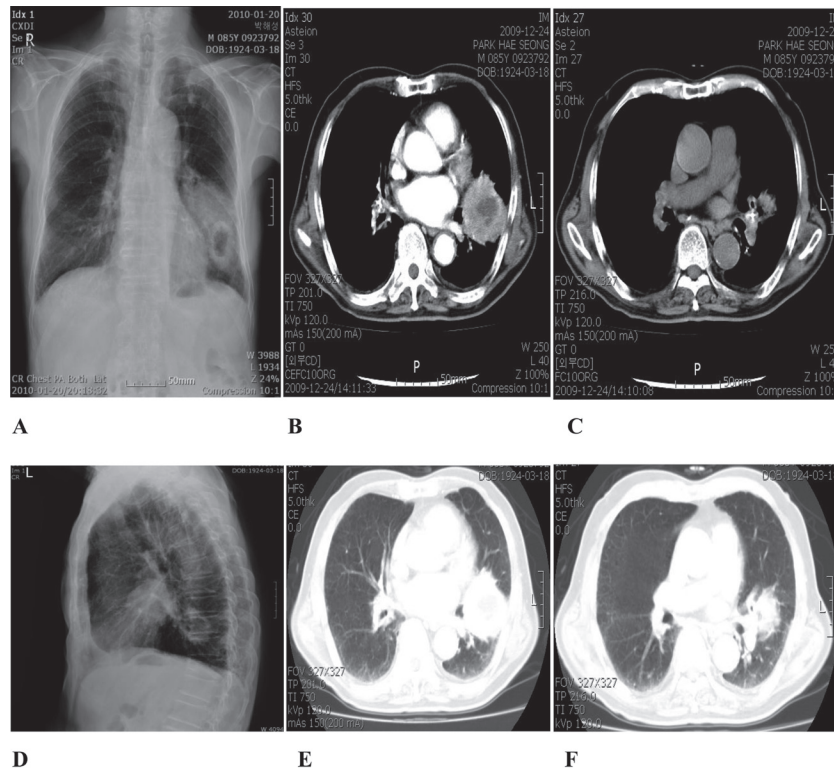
(A, D) Chest X-ray on admission shows a cavitory lesion with irregular opacities in left lower lung. (B, E) High-resolution CT shows a large, cavitory mass in the left lower lung field. (C, F) Non-enhanced CT shows irregular calcified opacities around tumor.
